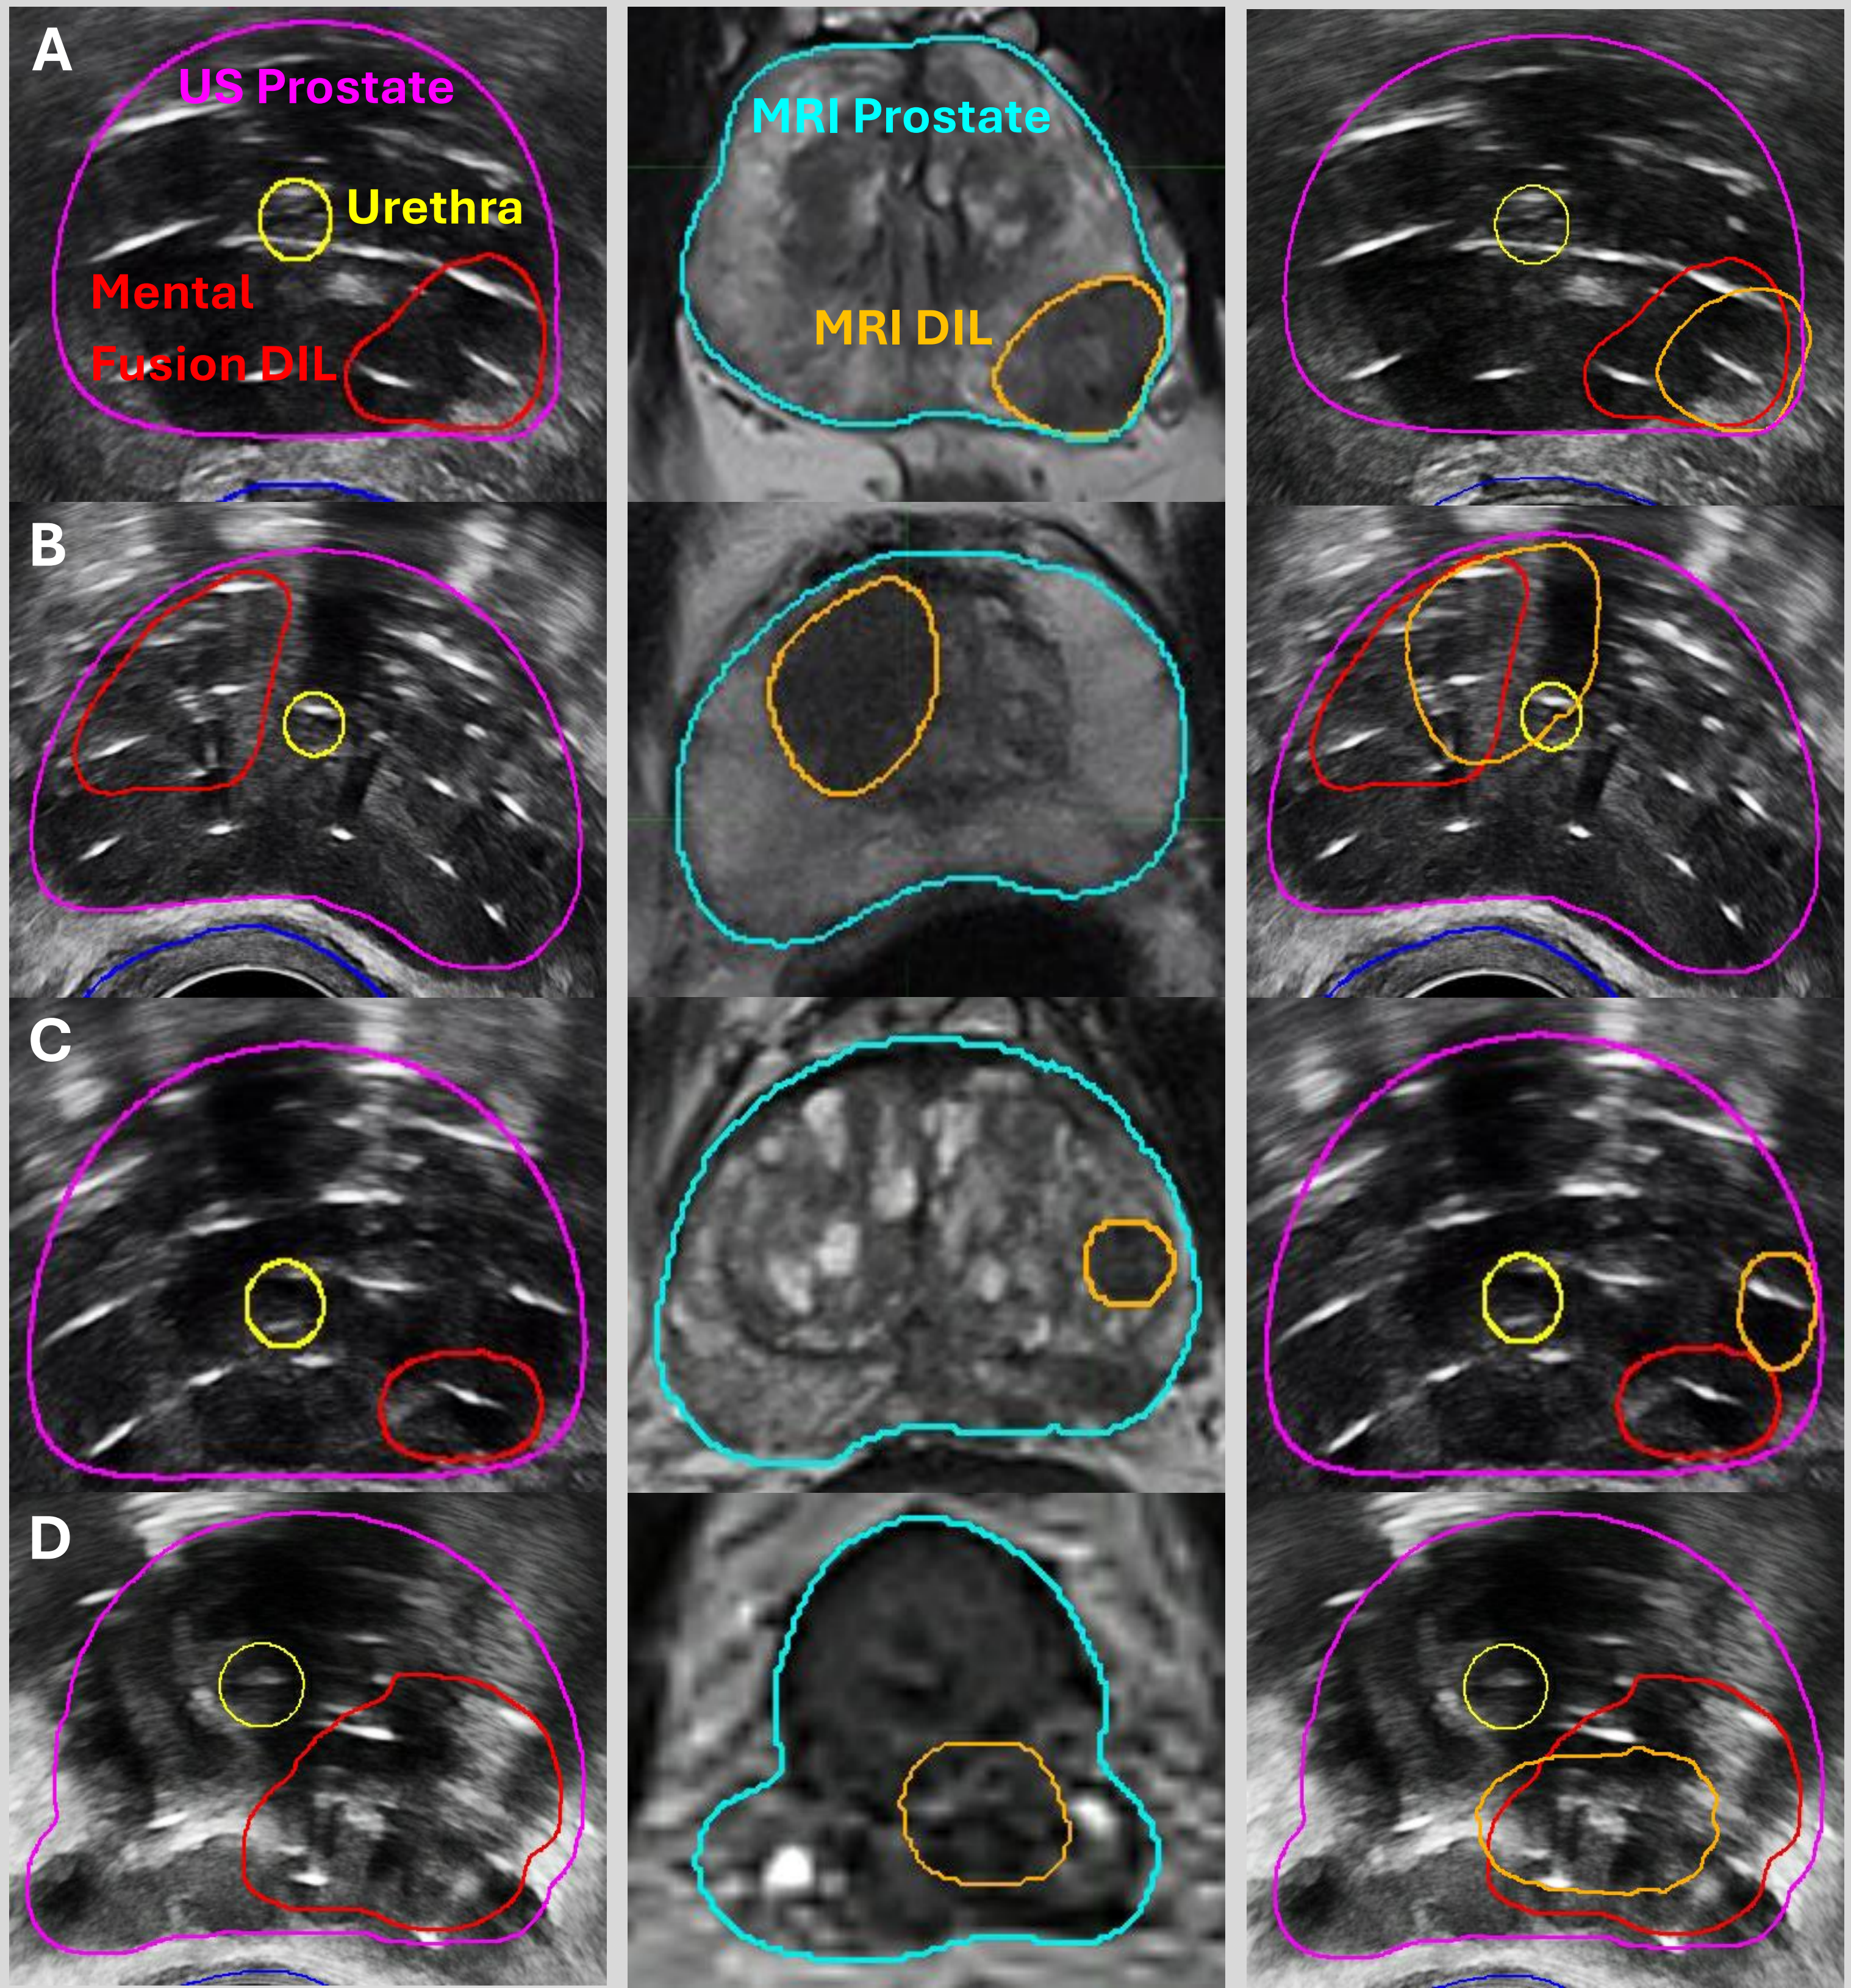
Three retrospective clinical cases (A, B, C) and one prospective case (D) showing an US image with mentally fused DIL (Left), pre-treatment MRI with defined DIL (Middle), and deformable image registration result with fused MRI DIL displayed on US (Right).
